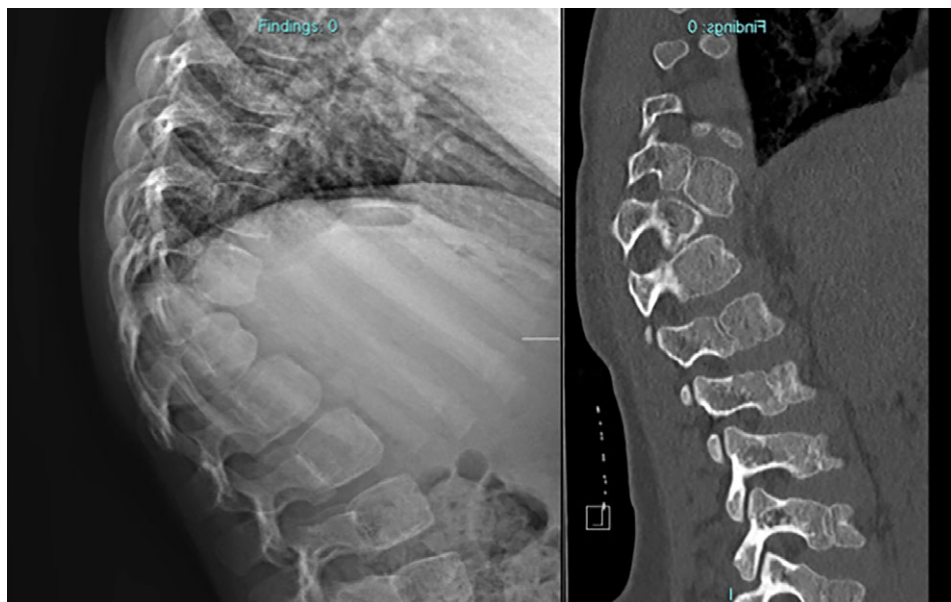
Thoracolumbar lateral radiograph (left) and CT sagittal reconstruction of same region (right)
